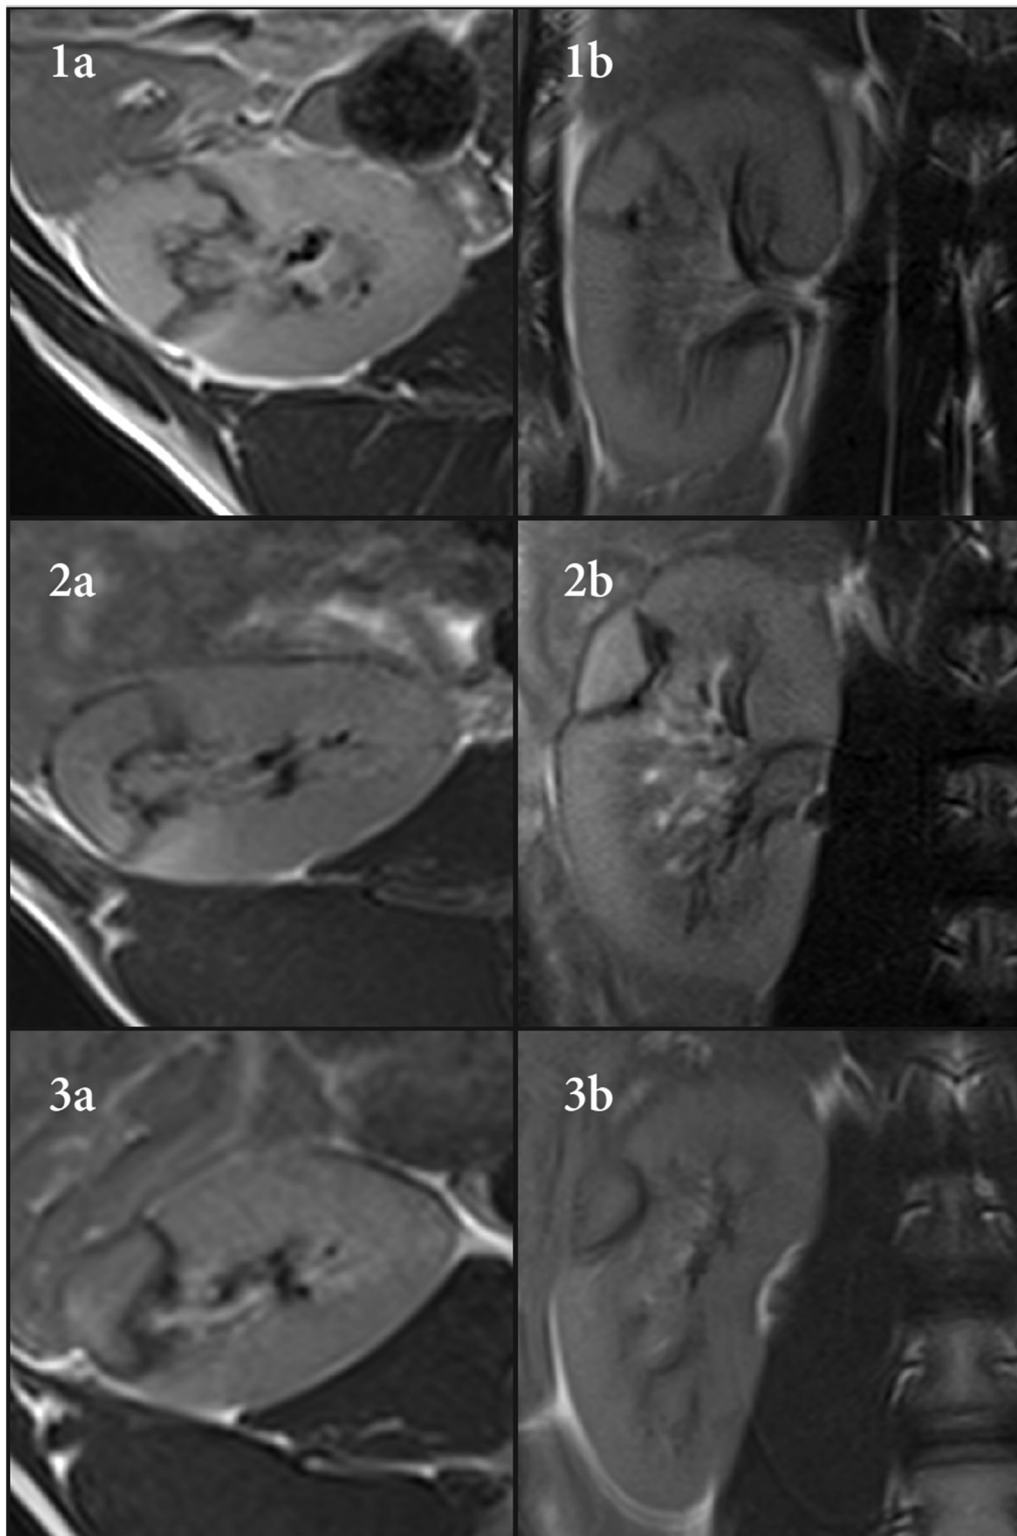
(MR). T2-weighted magnetic resonance imaging of the endophytic cryo lesions after one (1a/b), two (2a/b) and four weeks (3a/b) of follow-up. The cryo lesions are involving the entire renal parenchyma and extending into the renal sinus and collecting system. After four weeks (3a/b) the cryolesions decrease in size as the fibrotic transformation increases.
